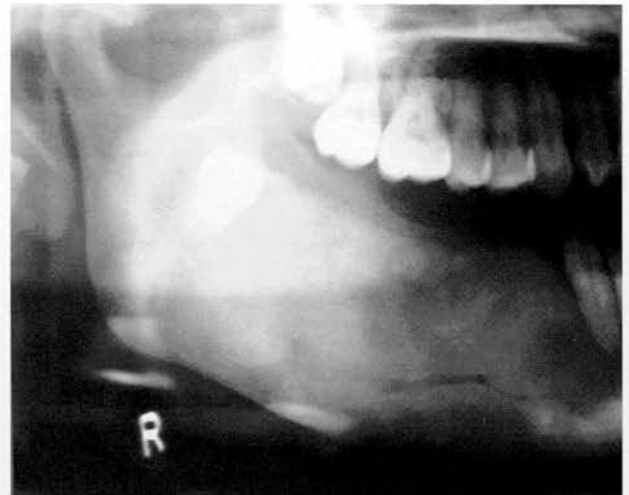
Part of a panoramic radiograph of a case of FD displaying fusiform expansion of the body of the mandible with downward displacement of the lower border and upward displacement of the alveolus. The dysplastic bone displays cotton-wool sclerosis. The normal/dysplastic bone interface is approximately sited in the middle of the ramus; the normal cortex delineating the normal follicle surrounding the crown of the unerupted third molar is only apparent distally, in normal bone. The inferior dental canal has been displaced downwards.
